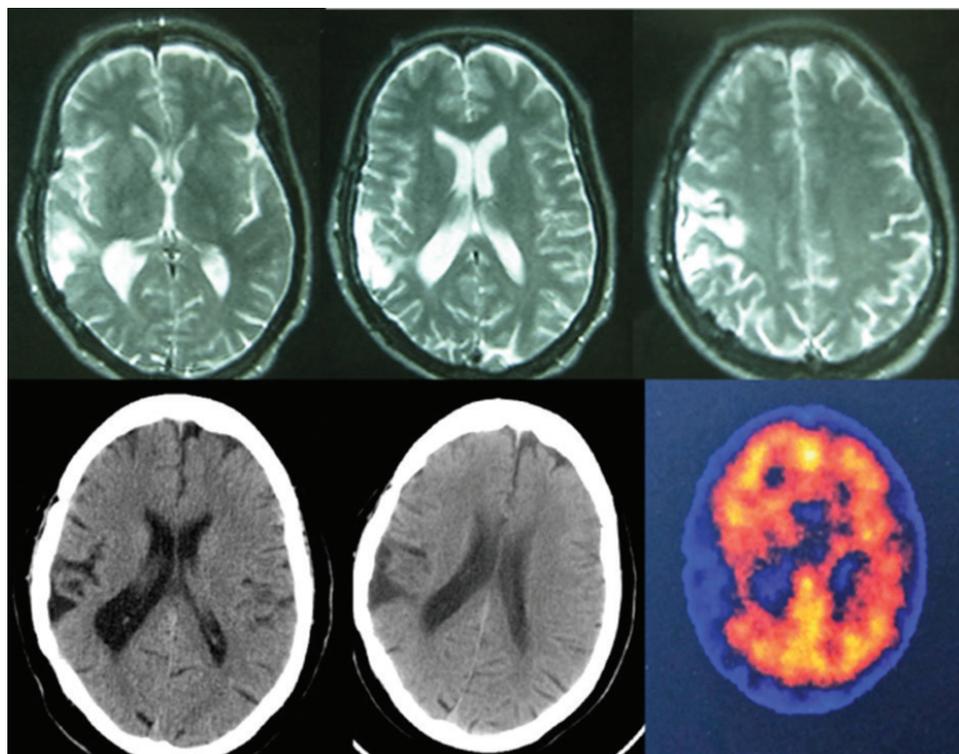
The magnetic resonance imaging (above) and computed tomography (CT) (below) scans show a large post-operative right corticosubcortical temporoparietal lesion corresponding to the remarkable hypoperfused area shown by the single-photon emission CT (below right)
